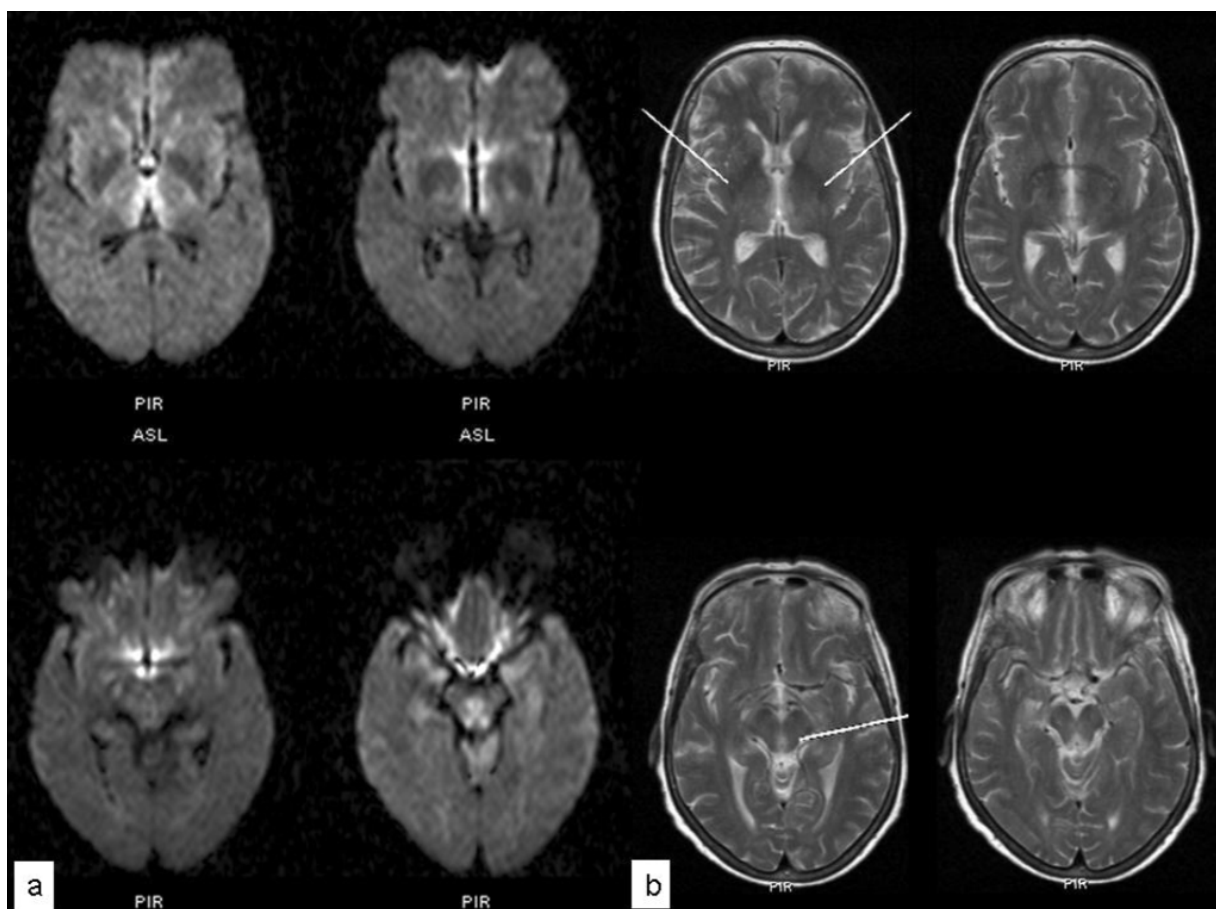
(a) Diffusion-weighted cranial MRI showing bilateral restricted diffusion in the mamillary bodies and in the periaqueductal grey matter. (b) T2-weighted imaging with hyperintensities in the same regions
